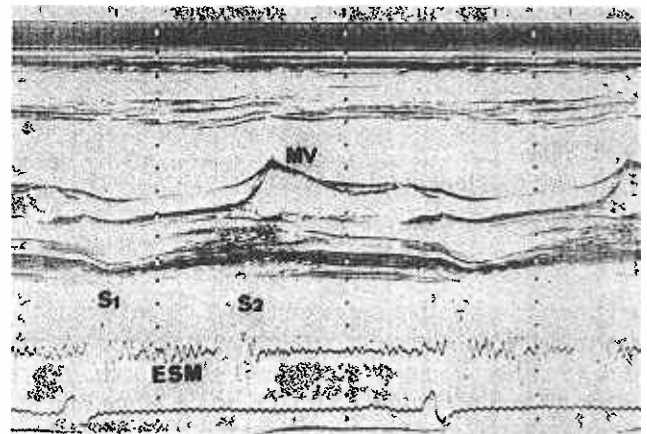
Simultaneous M Mode echocardiogram and phonocardiogram of Case 8. The echocardiogram shows a normal mitral valve. The phonocardiogram recorded at the pulmonary area shows an ejection systolic murmur and widely split second sound. S1 = first heart sound. S2 = second heart sound. ESM = ejection systolic murmur.
